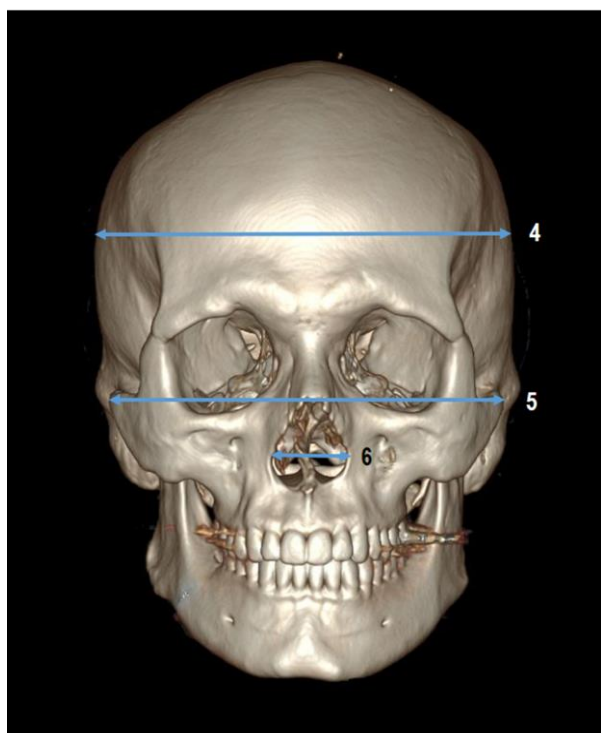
The representation of the 3 craniofacial parameters on 3D-CT reconstruction: 4) eu-eu; 5) zy-zy; 6) al-al
